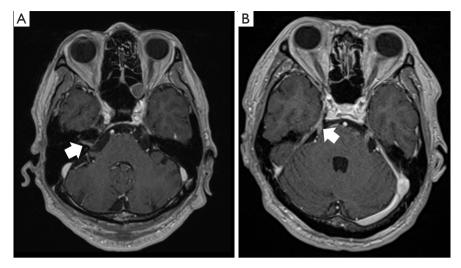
This neuroimaging shows cranial nerve damage, shown here as contrast images of the acoustic nerve in the internal auditory canal and the trigeminal nerve at the cerebellopontine angle. (A) T1WI-MRI in the patient with meningeal carcinoma demonstrates contrast enhancement in the right internal auditory canal (arrow). (B) T1WI-MRI with abnormal enhancement in the bilateral trigeminal nerves (arrow). T1WI, T1-weighted image; MRI, magnetic resonance imaging.
